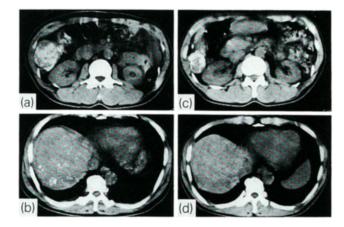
Treatment of new lesions in the liver. (a) CT scan, 7 days after initial administration of drug. (b) CT scan, 14 months after the first dose. New lesions in the right upper parts of the liver were observed. Because the primary tumour was not reduced in size, the drug was changed to the mixture. (c,d) CT scans, 24 months after treatment with the nuixture, the primary tumour was reduced in size, and new small lesions had disappeared.
